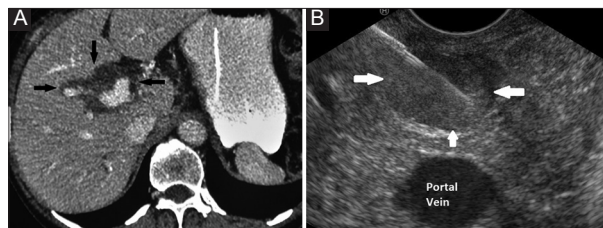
(A) Computed tomography: dilated central biliary radicles and upper common bile duct (arrows). (B) Endoscopic ultrasound: large mass lesion with heterogeneous echotexture, filling the lumen of the lower common bile duct (arrows). EUS guided fine needle aspiration being done
